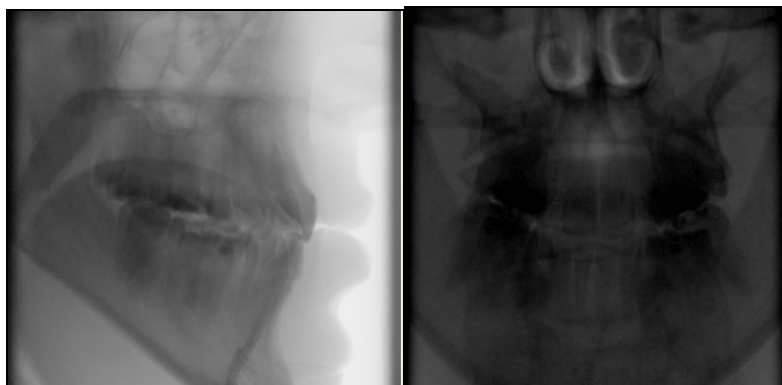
Variability of detector flux during CBCT exposure. Grey values are directly related to detector signal. Left: lateral projection angle with high detector signal. Right: frontal projection angle with lower detector signal.
